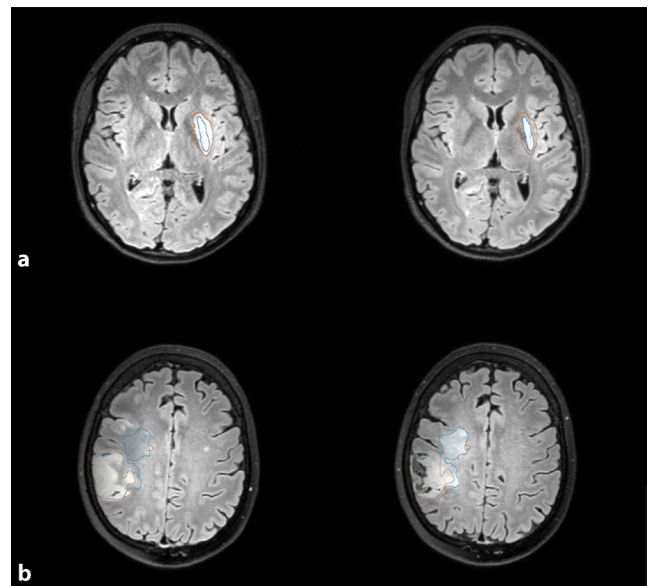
234 Example of two patients three days after mechanical recanalization of an acute M1-occlusion (FLAIR, on the left) and in the follow-up after three months (FLAIR, on the right). In (a) the stroke lesion (segmented in FLAIR 3 days after stroke, in orange) shows a decrease of >50 % in the follow-up imaging (segmented in FLAIR after 3 months, in blue), in (b) the stroke lesion increases after 3 months
